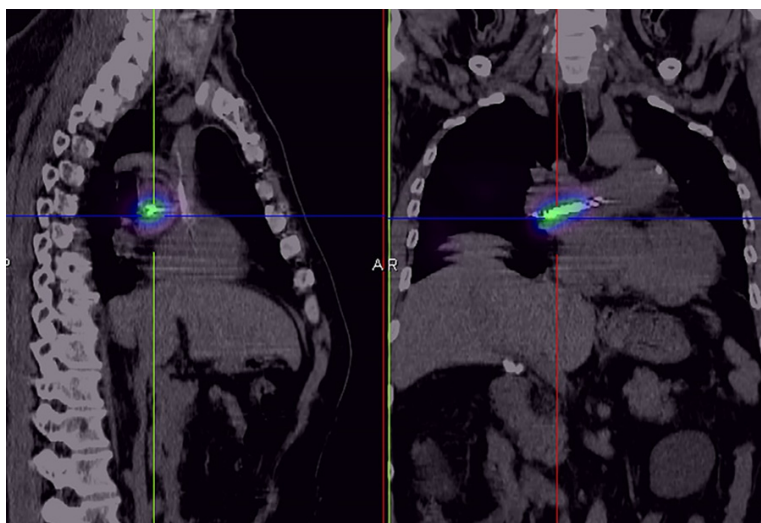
SPECT/CT tomography images after ^{125}I -seeds implantation treatment. A bead-like seeds with metallic density was seen in the right pulmonary artery, with obvious radioactive distribution, indicating well-positioned covering the tumor area.
